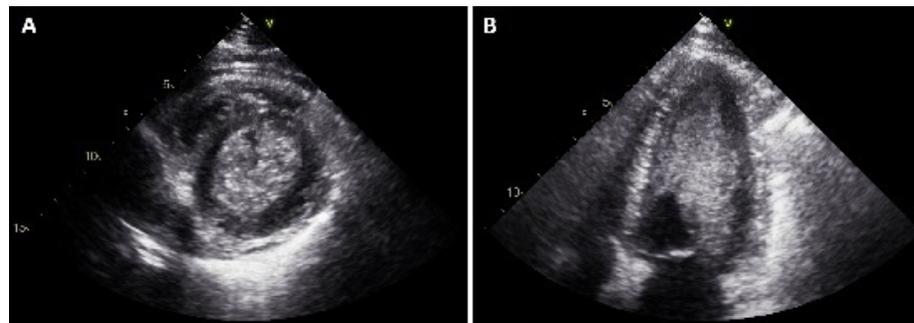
Echocardiography showed hyperechoic thickening of the endocardium and apical cavity obliteration. (A) Mid-level short axis view at systole, (B) Apical 4 chamber view at systole
